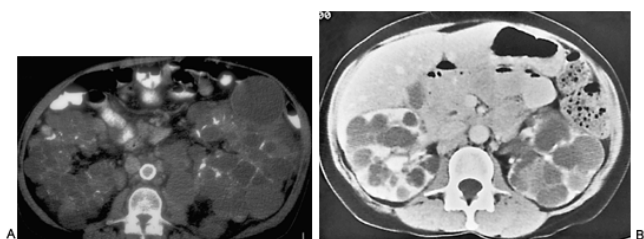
Autosomal-dominant polycystic kidney disease in two adults. A: Unenhanced computed tomography (CT) scan revealing calcifications in walls of multiple cysts in enlarged kidneys. B: Enhanced CT scan in a 51-year-old woman reveals bilaterally markedly enlarged kidneys with multiple cysts of varying sizes, shapes, and attenuation values. There is some enhancing renal cortical tissue remaining, but excretion into the collecting system is identified only with difficulty.
